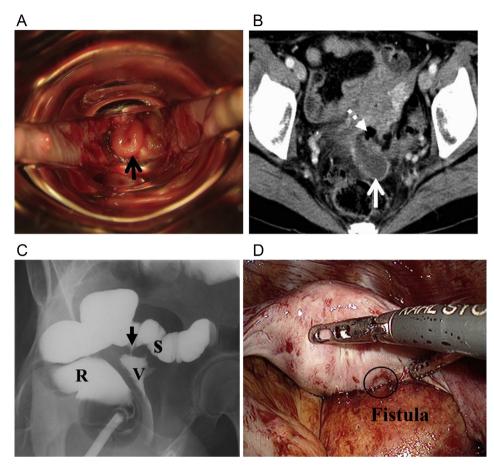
(A) The intestinal mucosa could be visualized from the vaginal cavity on Cusco examination. (B) Computed tomography image shows a suspected fistula between the uterine cervix and sigmoid colon. (C) When the contrast agent was injected into the intestine, leakage from the sigmoid colon to the vagina cavity was observed. (D) A fistula measuring approximately 1 cm in diameter was observed in both the sigmoid and the uterine rear wall. R = rectum; S = sigmoid colon; V = vaginal cavity.
